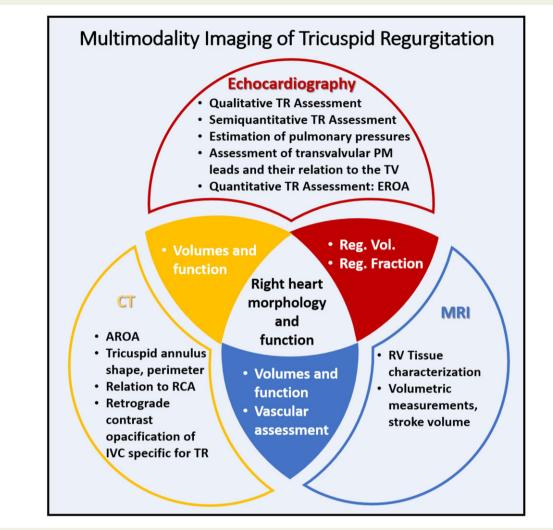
Multimodality assessment of tricuspid regurgitation severity. Different imaging methods give complementary information about tricuspid regurgitation aetiology, anatomic and functional substrates as well as TR severity. AROA = anatomic regurgitant orifice, EROA = effective regurgitant orifice area, CT = computed tomography, IVC = inferior vena cava, MRI = magnetic resonance imaging, PM = pacemaker, RCA = right coronary artery, Reg. Fraction = regurgitant fraction, Reg.Vol. = regurgitant volume, RV = right ventricle, TR = tricuspid regurgitation, TV = tricuspid valve.
